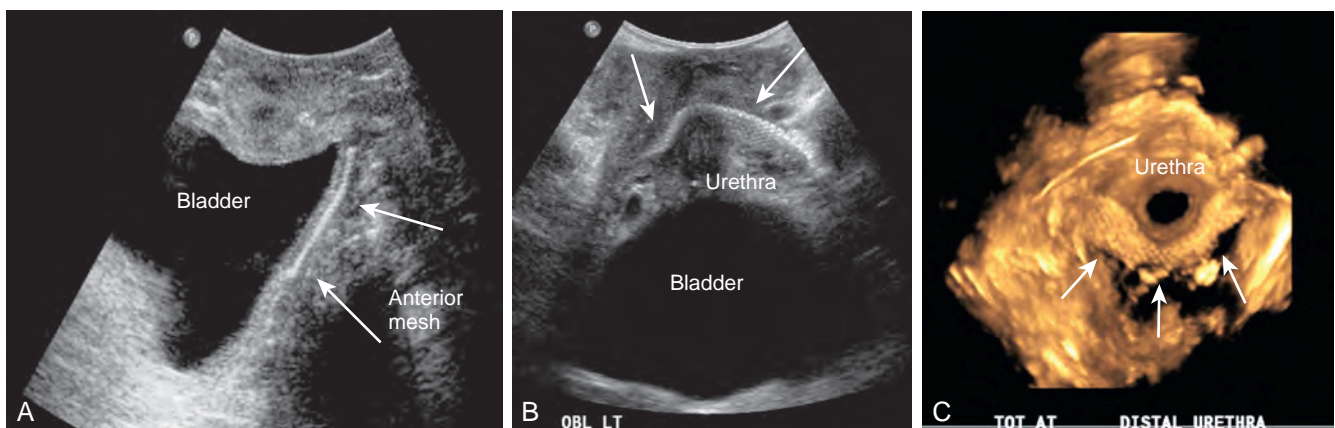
Translabial ultrasonography. A, Anterior vaginal synthetic graft (arrows), two-dimensional sagittal view. B, Mid-urethral synthetic sling (arrows), two-dimensional oblique view. C, Mid-urethral synthetic sling, no penetration of periurethral fascia (arrows), three-dimensional reconstruction.
